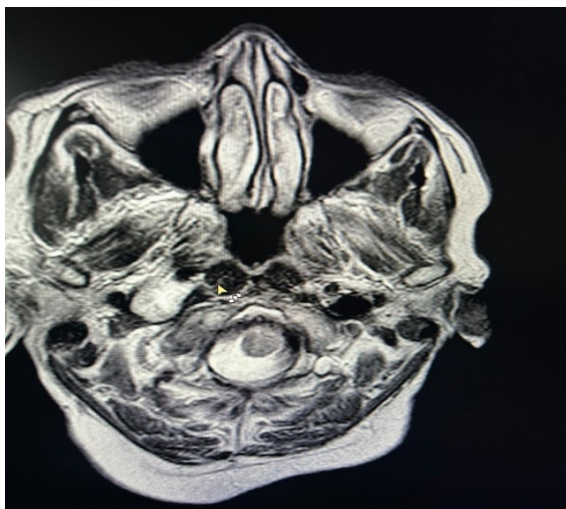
Axial T2-weighted MRI demonstrating a right jugular foramen vagal nerve schwannoma extending into the carotid sheath with displacement of adjacent neurovascular structures.
